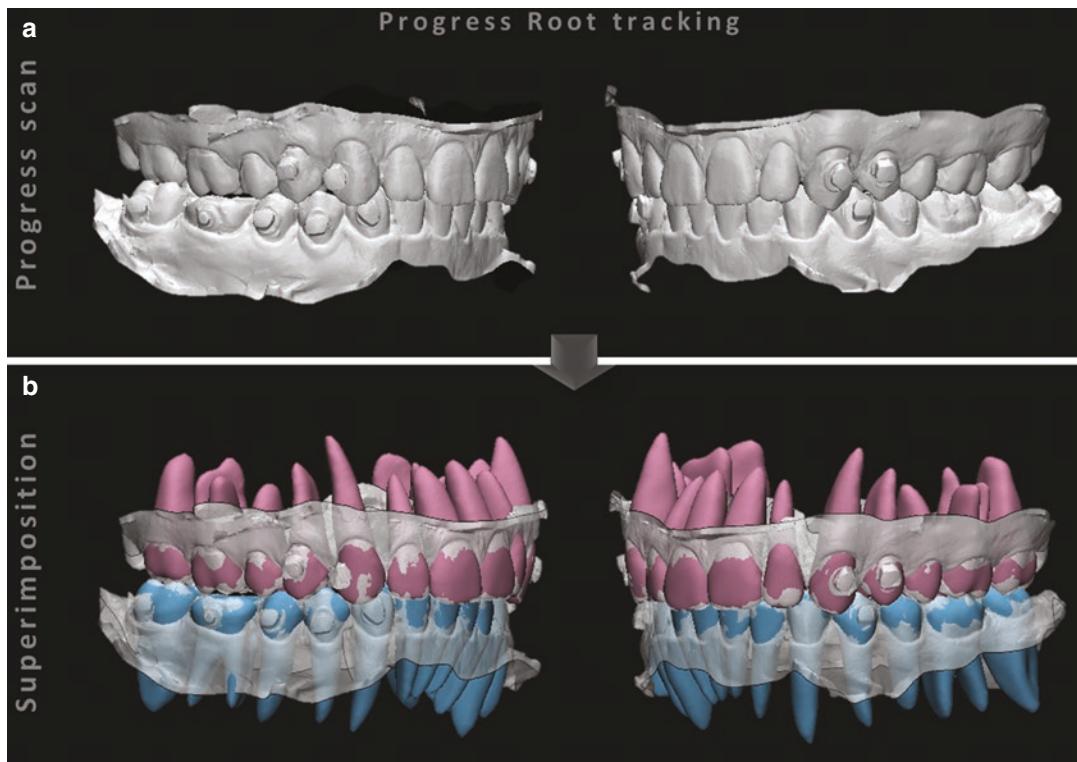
(a) Scan taken during treatment. (b) The crown and roots from the pretreatment CBCT were merged into the new position so the doctor can track root position without additional radiation
